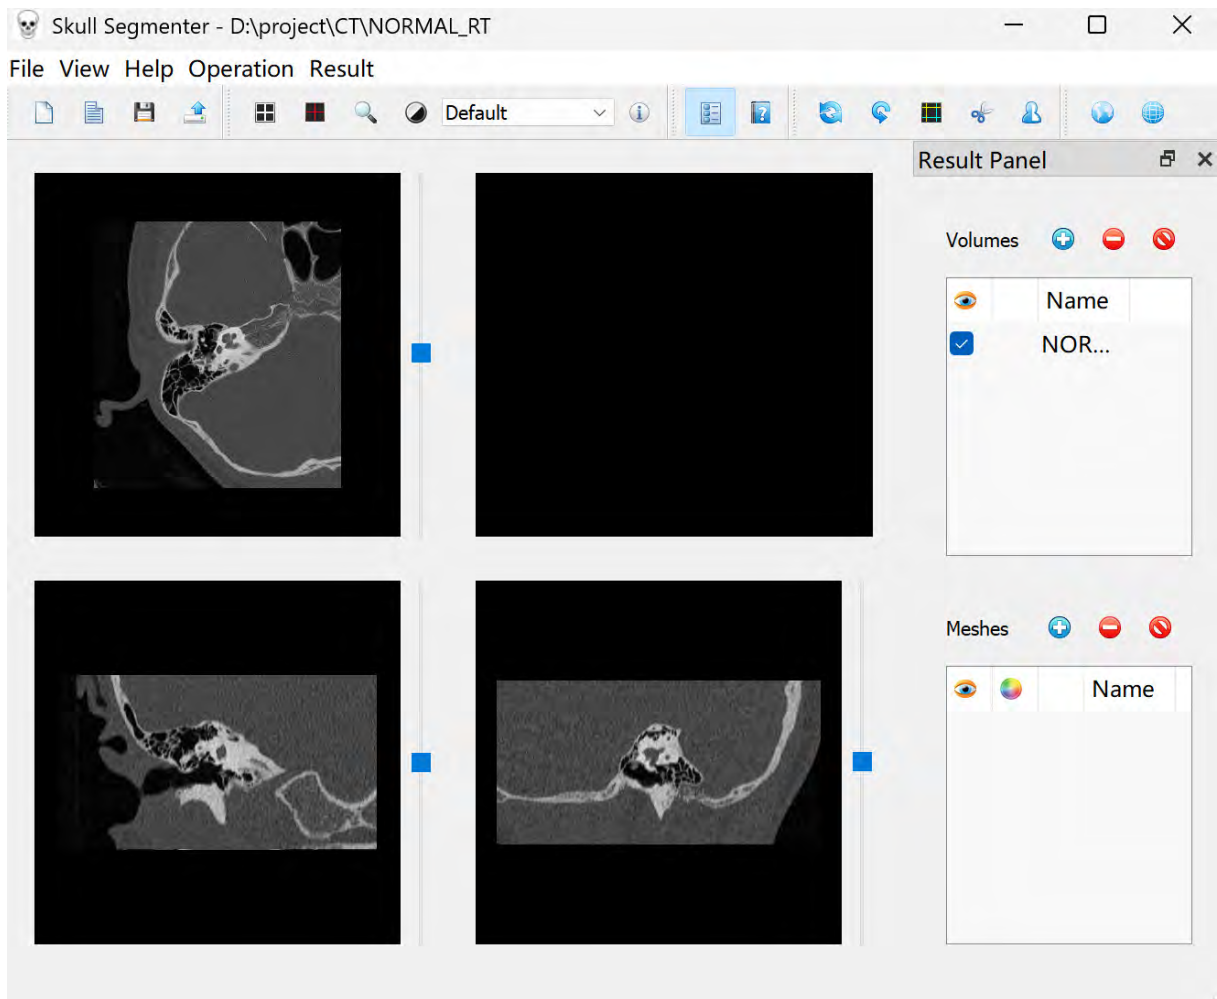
Overall GUI of the segmentation tool. After successfully reading normal right ear CT file, the corresponding slices can be seen in three 2d plane windows.
